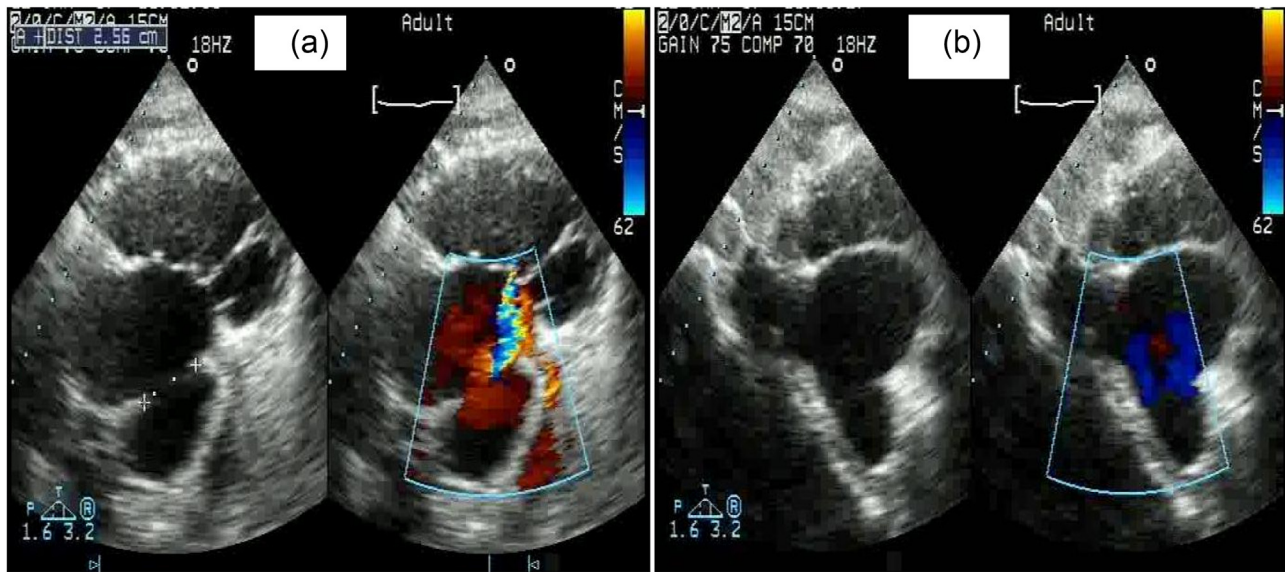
Echocardiography with color Doppler in subcostal view. 1(a) Ostium Secundum ASD with left to right flow and mild tricuspid regurgitation, 1(b) Total absence of IVC and aortic rim.
